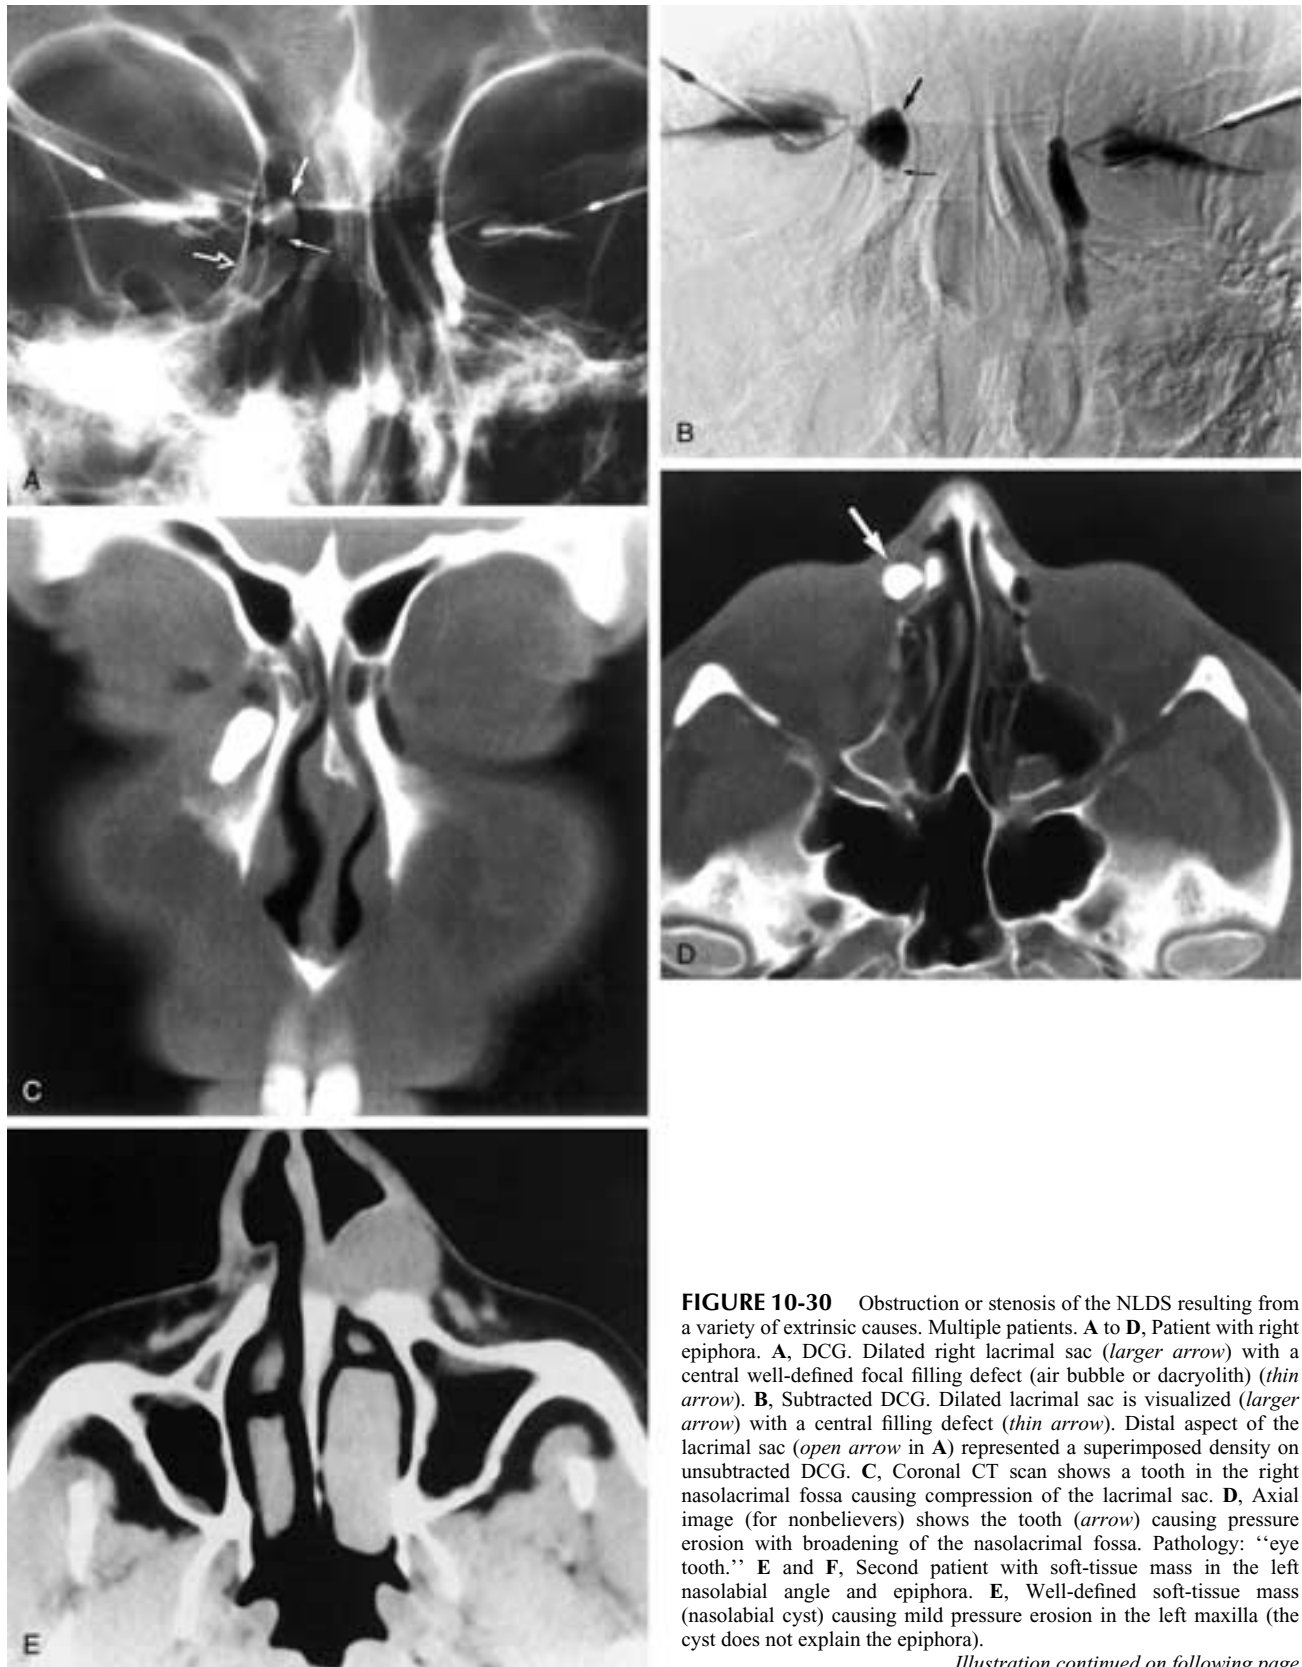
Obstruction or stenosis of the NLDS resulting from a variety of extrinsic causes. Multiple patients. A to D, Patient with right epiphora. A, DCG. Dilated right lacrimal sac (*larger arrow*) with a central well-defined focal filling defect (air bubble or dacryolith) (*thin arrow*). B, Subtracted DCG. Dilated lacrimal sac is visualized (*larger arrow*) with a central filling defect (*thin arrow*). Distal aspect of the lacrimal sac (*open arrow* in A) represented a superimposed density on unsubtracted DCG. C, Coronal CT scan shows a tooth in the right nasolacrimal fossa causing compression of the lacrimal sac. D, Axial image (for nonbelievers) shows the tooth (*arrow*) causing pressure erosion with broadening of the nasolacrimal fossa. Pathology: “eye tooth.” E and F, Second patient with soft-tissue mass in the left nasolacrimal angle and epiphora. E, Well-defined soft-tissue mass (nasolacrimal cyst) causing mild pressure erosion in the left maxilla (the cyst does not explain the epiphora).
